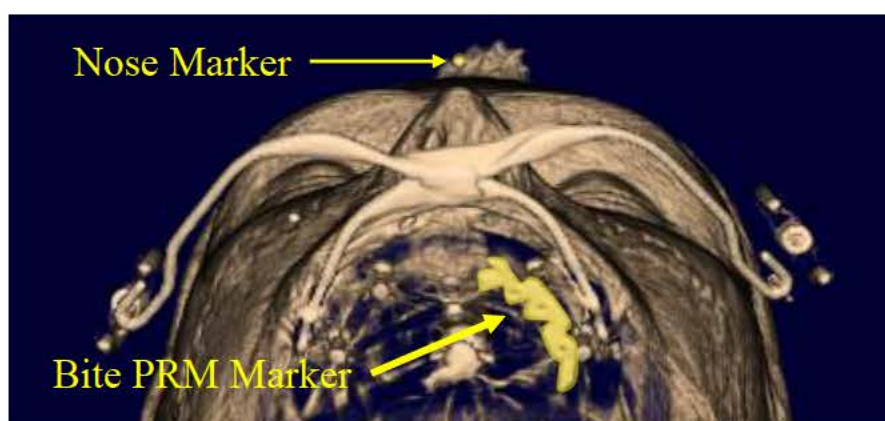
Automatic Detection of the Embedded CT Marker
